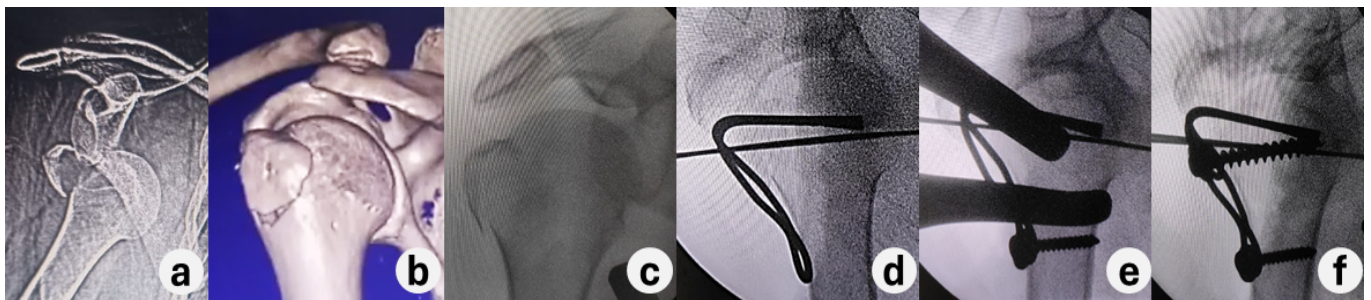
(a) AP shoulder radiograph showing GT fracture associated with anterior GH dislocation; (b) Post reduction 3D CT reformat confirming reduction and excluding concomitant fractures; (c) Intraoperative fluoroscopic image showing reduction of GT; (d) Temporary fixation with K-wire and insertion of the horizontal limb of MHW device after predrilling; (e) Insertion of a bi-cortical distal screw of appropriate length into the humeral shaft in eccentric position via the inferior oblong hole of the device; (f) Insertion of a fully cancellous superior screw of appropriate length through the superior oblong hole to fix the GT anatomically.
